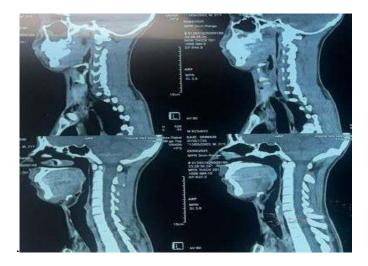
Cervicothoracic computed tomography (CT) scan revealing extensive bilateral subcutaneous emphysema extending into the retropharyngeal spaces and superior mediastinum, without a visible laryngotracheal defect.
